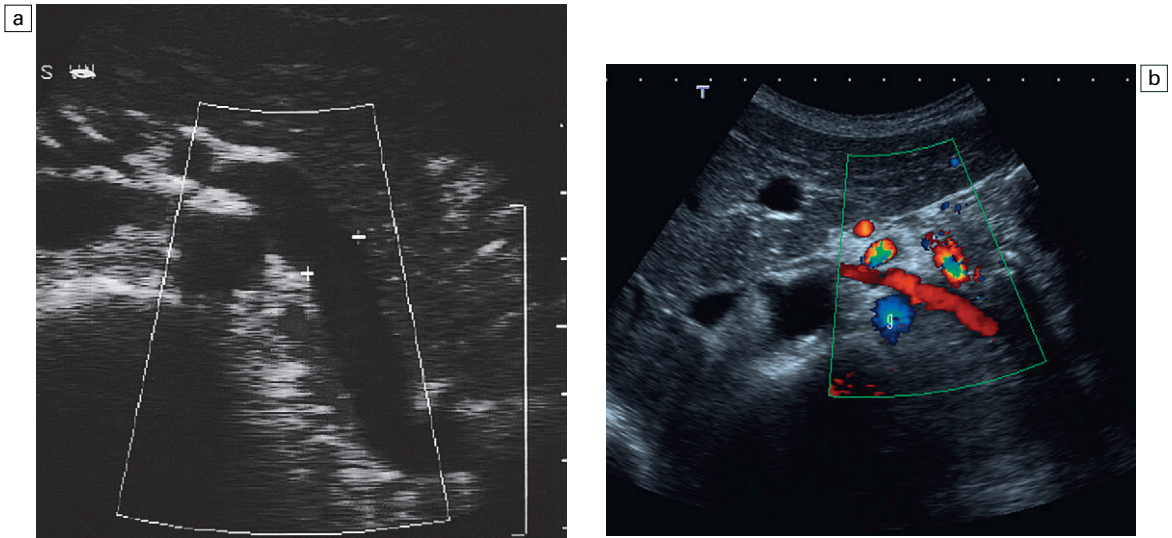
(a) (b) Colour flow Doppler demonstrating flow towards the transducer in the left renal vein. A large gonadal vessel is demonstrated posteriorly (g).
